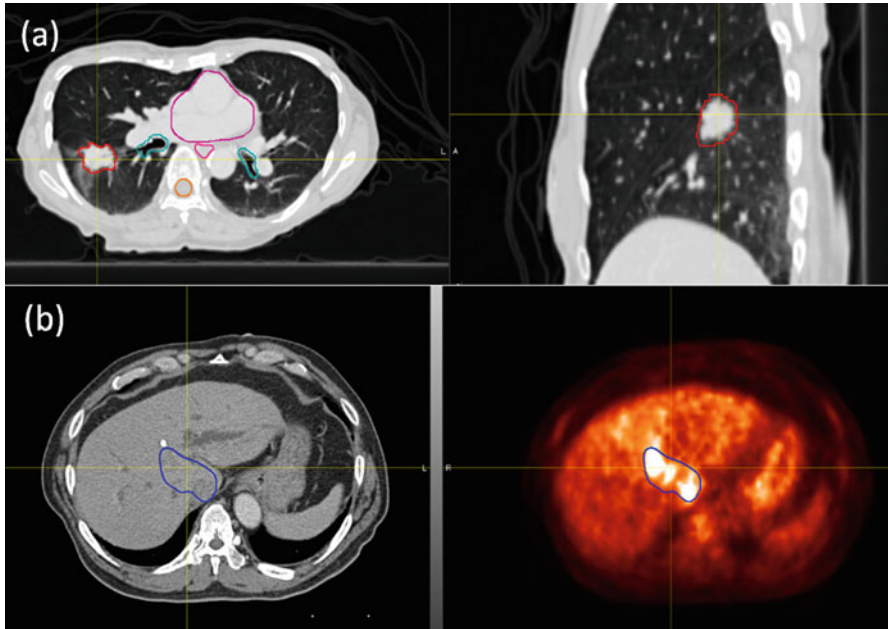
(a) Axial and sagittal CT images showing a lung tumor delineated by red contour and major organs at risk outlined. (b) *Left*: a liver lesion outlined by the blue contour which can be barely differentiated from the surrounding normal liver tissues due to the low soft tissue contrast of CT image. *Right*: the liver lesion can be better delineated on PET image
